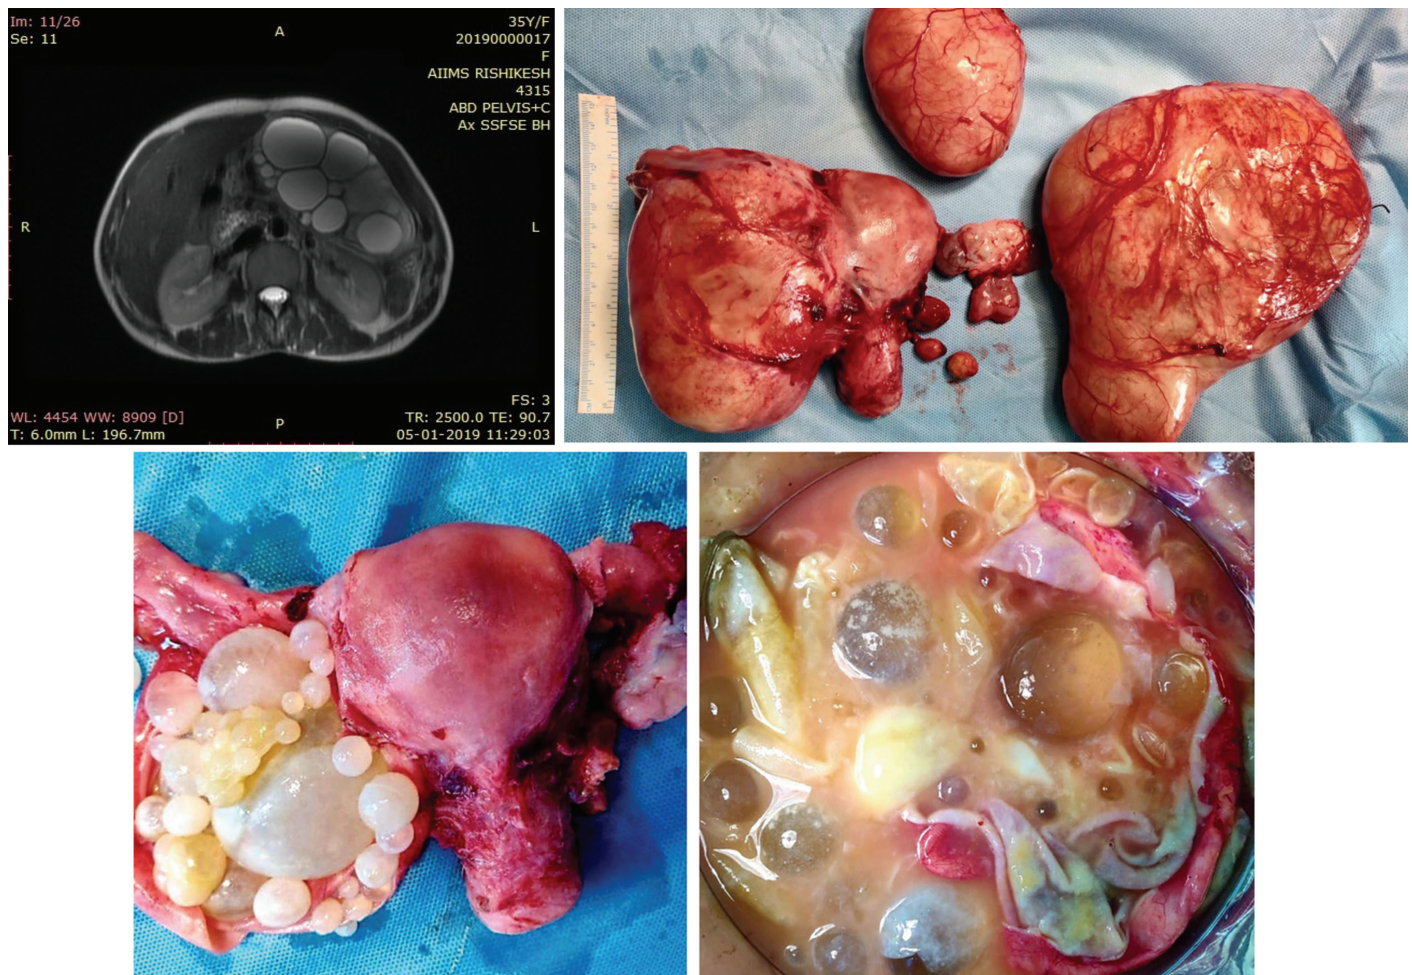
T2-weighted magnetic resonance imaging image showing smooth walled clusters of fluid signal cystic lesion in the pelvis with clusters of multiple tiny fluid signal cysts. Intra-operative finding showing multiple fluid filled cysts in the ovary and omentum
